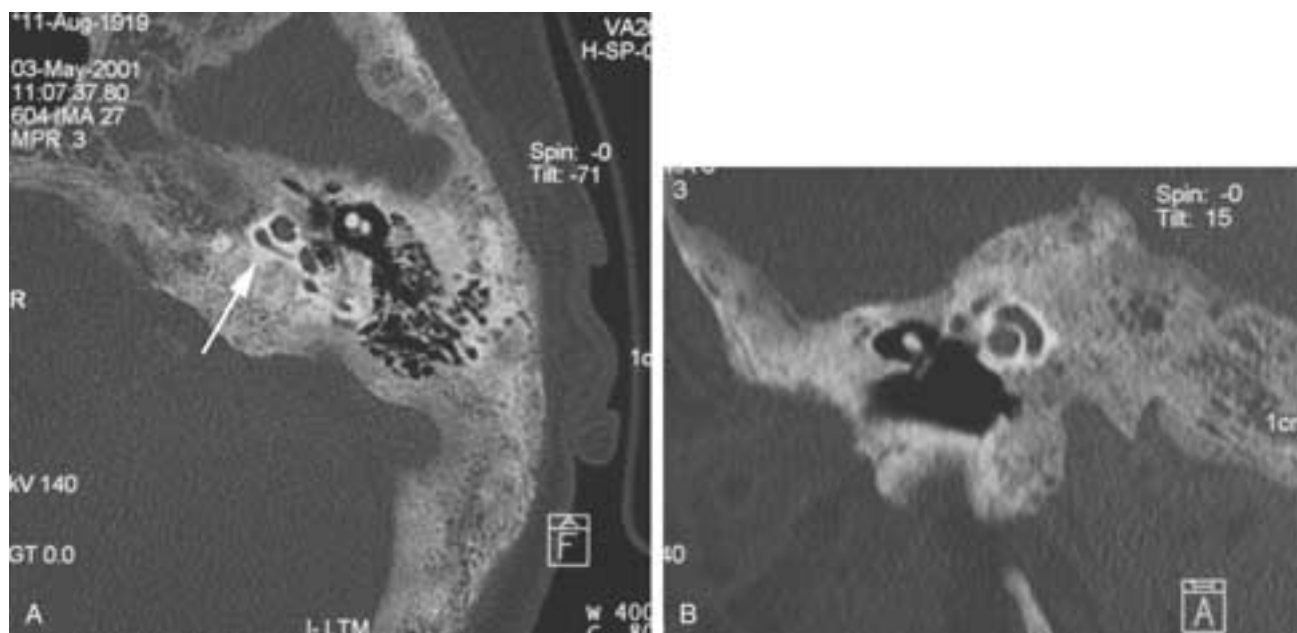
Paget's disease, CT scan. A, The bone has increased in size. There is demineralization and thinning of the otic capsule (*arrow*). B, Coronal image showing thinning of the otic capsule.
